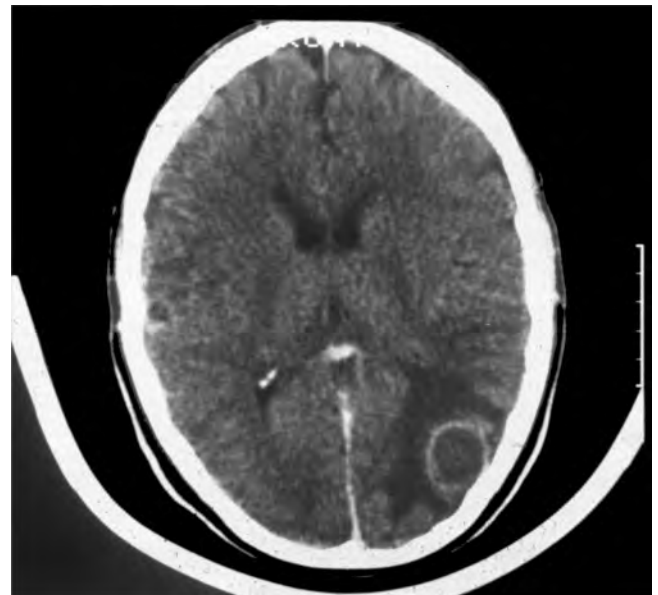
Mycotic aneurysm in *Streptococcus viridans* endocarditis (CT enhanced).
